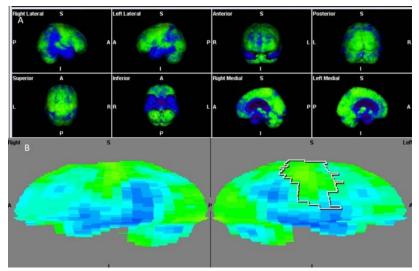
56 year male presented with progressive forgetfulness for 1 year. (A) Brain FDG PET/CT 3-D volumetric images revealed hypometabolism in the temporoparietal region. (B) SPM images revealed significant symmetrical hypometabolism in the temporoparietal region. The findings were consistent with Alzheimer's Disease.
